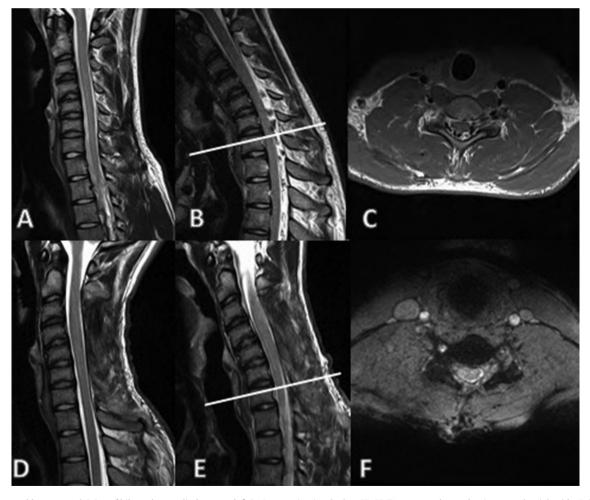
A 16-year-old man complaining of bilateral upper limb motor deficit. On examination, he has C7-C8-T1 amyotrophy predominant on the right side. Spinal MRI does not show any obvious abnormality (A). Dynamic MRI reveals canal stenosis due to large dilated epidural plexus resulting in impingement of the spinal cord at C3 to C7 (B), which was confirmed by axial sequences (C). C3 to C7 laminectomy was performed resulting in almost complete neurological recovery. Four-month postoperative MRI confirms the reappearance of CSF in neutral flexion (D), and absence of cord stenosis in dynamic views (D). Axial sequences did not show any recurrence of dilated plexus (E).
